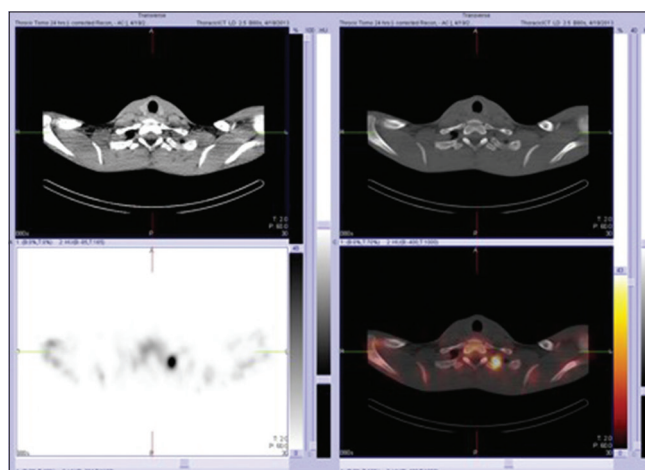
Bone scintigraphy with ^{99m}Tc-methylene diphosphonate. Single-photon emission computed tomography image revealed a solitary focal area of intense increased uptake of methylene diphosphonate on the left side of T1 vertebra (lower left image). The fused single-photon emission computed tomography-computed tomography image (lower right image) localized the focal area of uptake to a lytic lesion in the vertebral end of the left first rib
